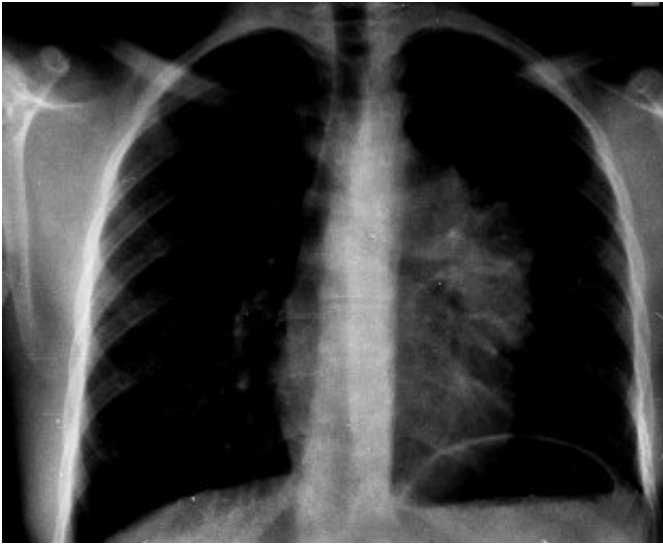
Patient 2. Roentgenogram shows large mediastinal mass.
